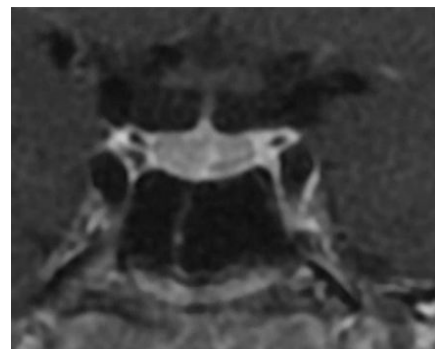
Two years later, MRI was normalized.
